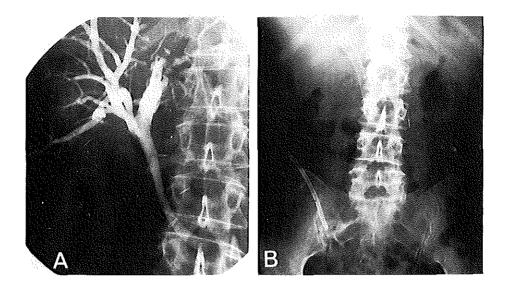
Images from a patient with inoperable pancreatic carcinoma and a blocked endoprosthesis placed by means of endoscopy. (a) The stenosis in the distal part of the CBD is "overstented" from the hilar region to the duodenum. (b) Plain radiograph obtained five days later shows that the stent has almost fully expanded. The shortened stent retains the form of the CBD. The blocked endoprosthesis, which was pushed into the duodenum, is now seen in the right lower quadrant of the abdomen.
